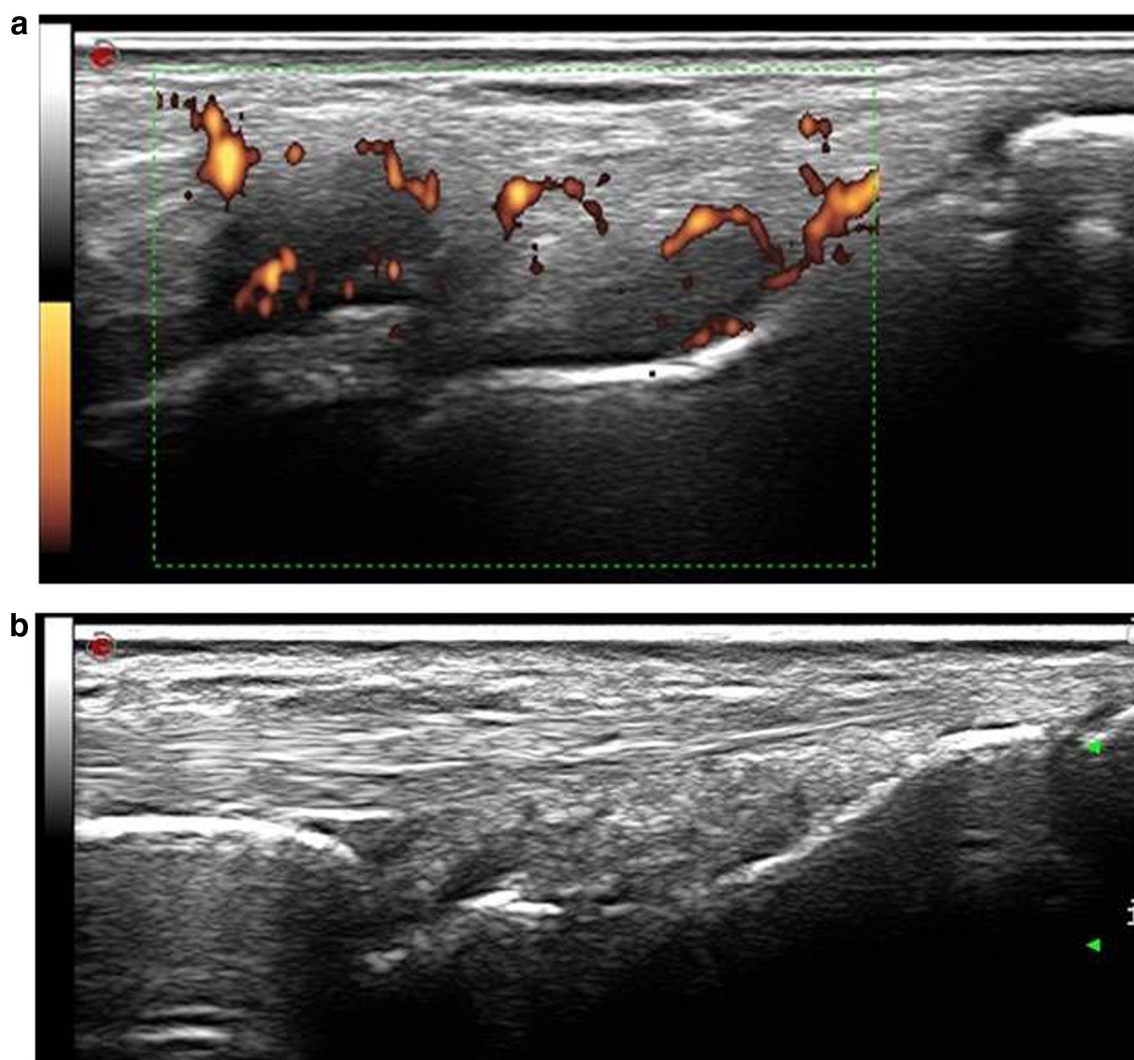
Representative image showing the modifications of US assessment at level of radiocarpal joints at baseline (a) and after 12 weeks of treatment (b) with apremilast. In a, an active synovitis (with positivity for power Doppler); b documented the resolution of this inflammatory status during treatment
